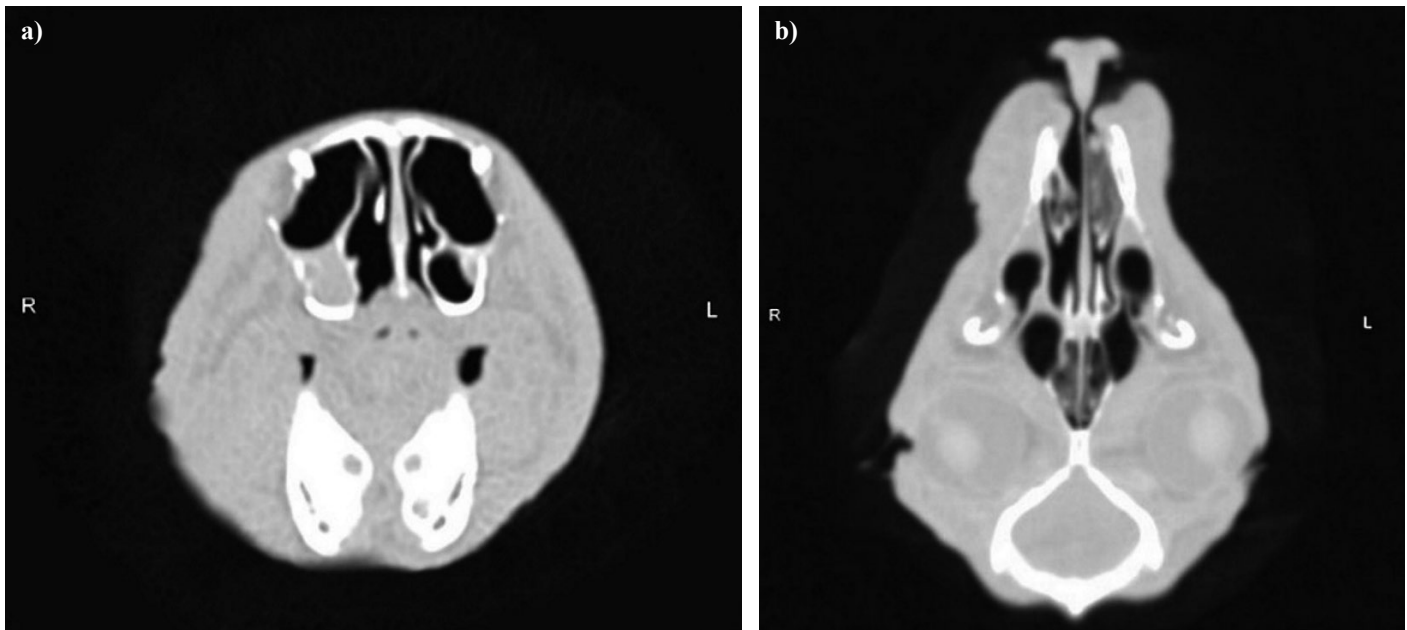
CT scans: a) AP projection; b) DV projection
